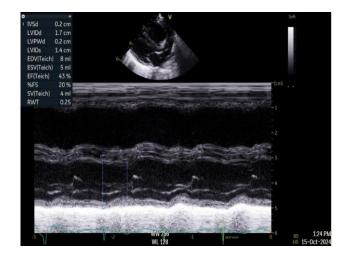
Parasternal long axis view showing mild to moderate depressed LV function.
